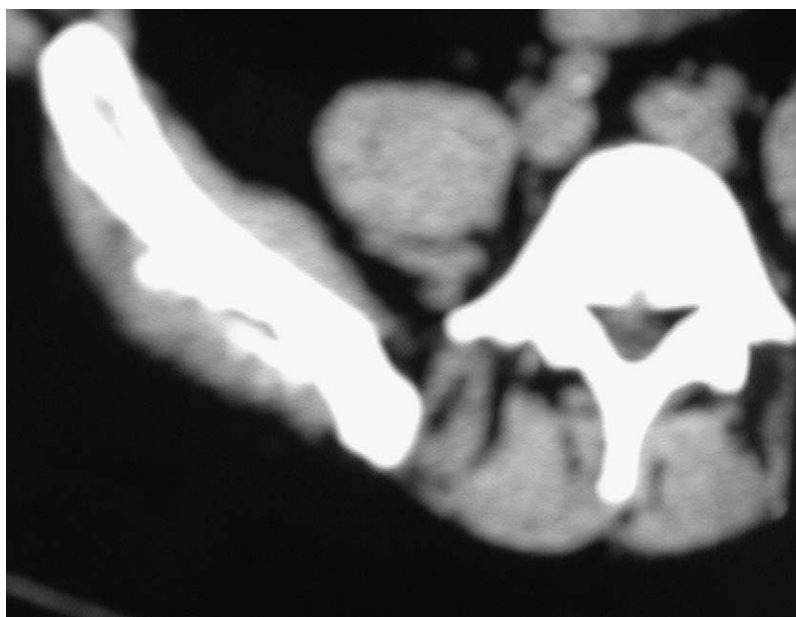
Six months postoperatively, the axial two-dimensional computed tomographic soft-tissue image demonstrated near complete incorporation of the B-TCP granules into the posterior iliac crest donor site.
